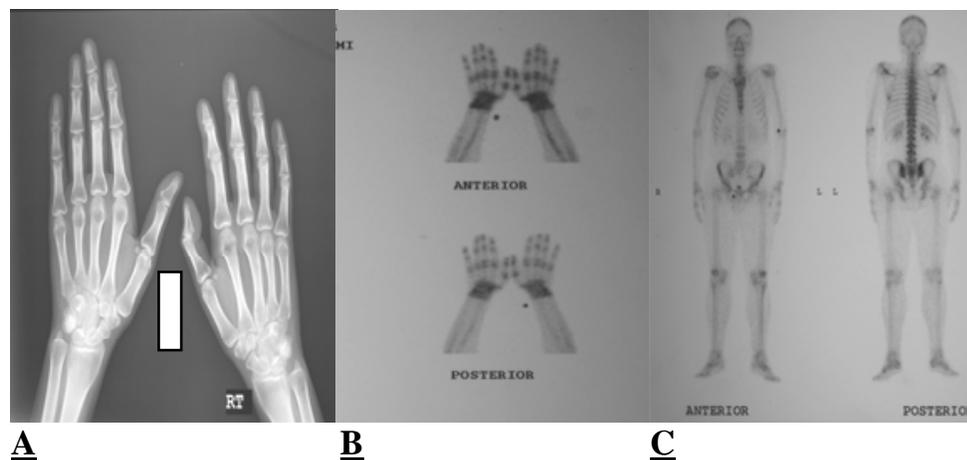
Radiographic and scintigraphic features of a BD patient. (A) Plain x-ray of hands showing juxta-articular osteopenia. (B) Bone scans of both hands showing increased uptake in bilateral wrists, Metacarpophalangeal & proximal interphalangeal joints. (C) Whole body scans with no other articular abnormalities.
